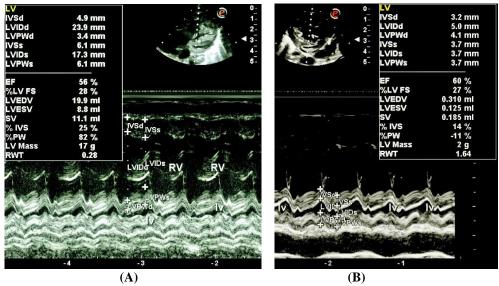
M-mode Echocardiography. (A) RV volumetric estimation; (B) LV volumetric estimation.
